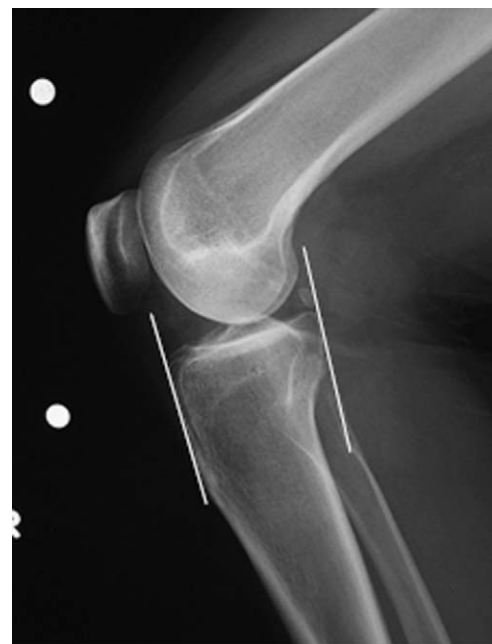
Preoperative lateral radiograph used for meniscal sizing. Meniscal length is determined by the tibial plateau distance measured at the joint line between a line parallel to the anterior tibia above the tuberosity and one tangential to the posterior plateau margin perpendicular to the joint line.
